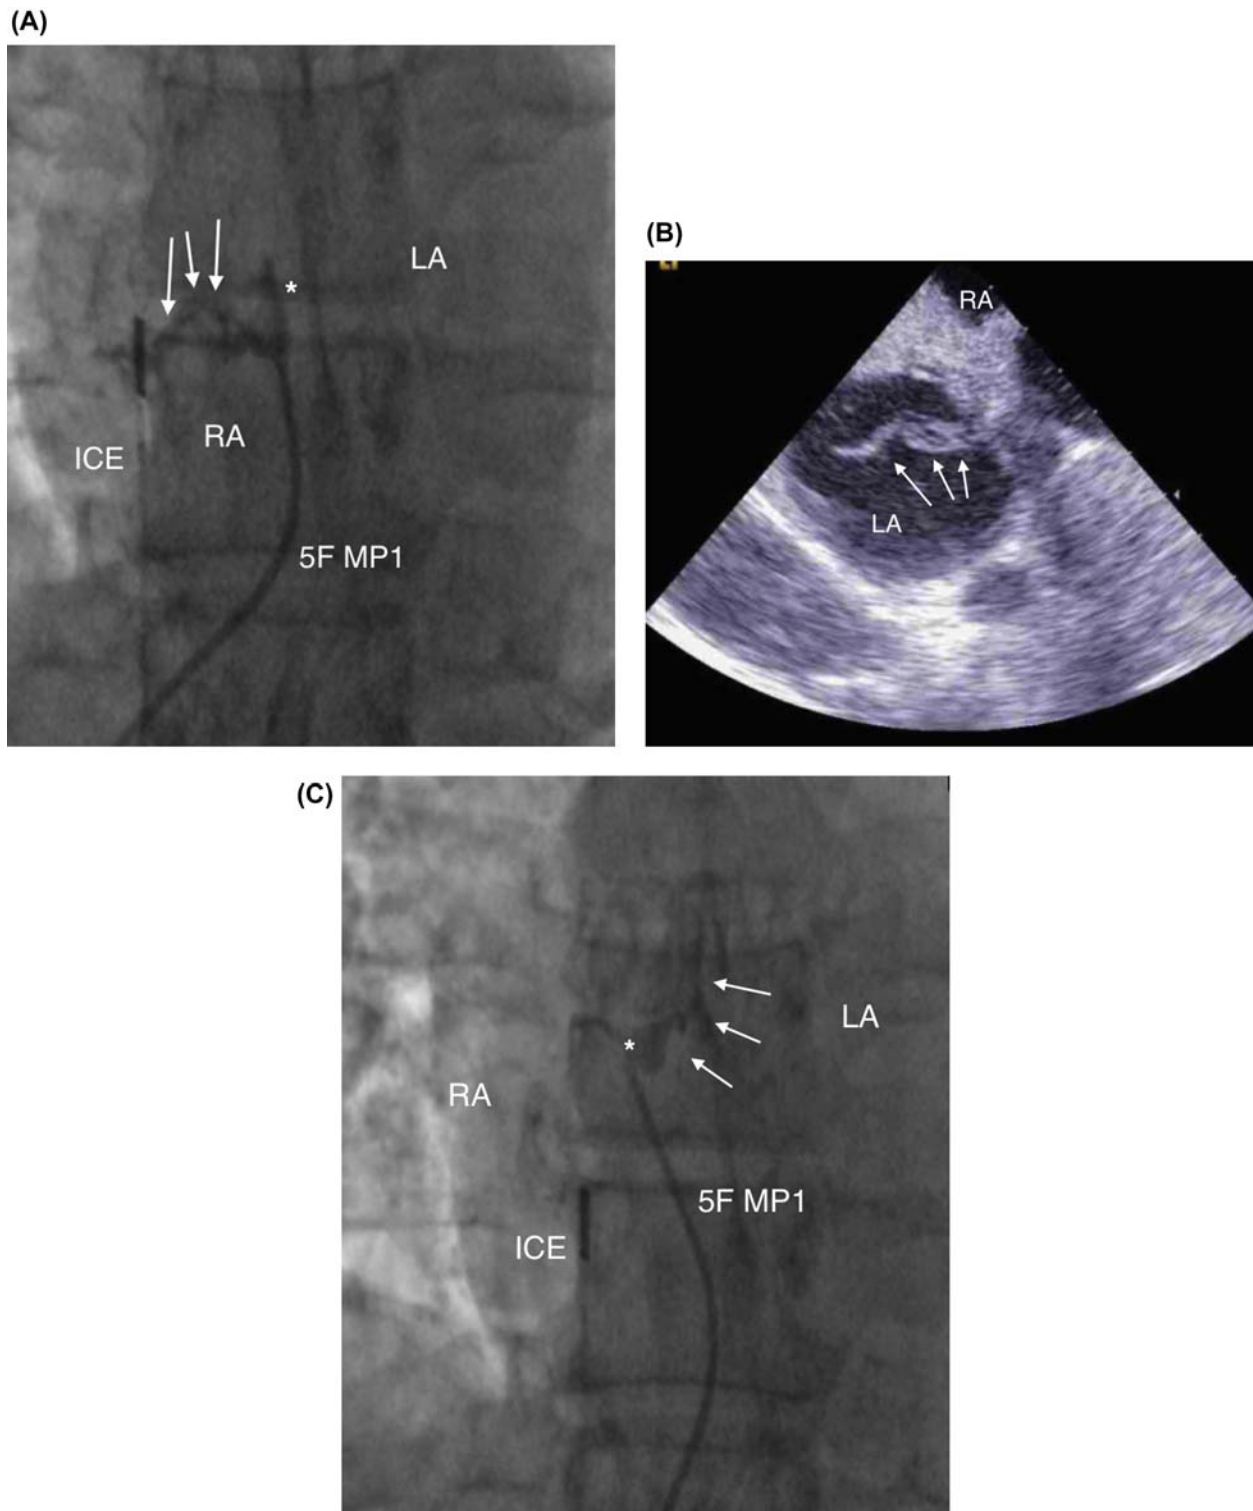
(A) Fluoroscopy of an intracardiac echocardiography (ICE) imaging catheter on the left side of the image with a 5F MP1 catheter engaged into the foramen ovale (asterisk), filling it with contrast medium and the contrast medium is seen spilling back (arrows) into the right atrium (RA) without any entering the left atrium (LA), suggesting a sealed foramen ovale pouch. (B) An intracardiac echocardiography image of the interatrial septum during agitated saline contrast medium injection under Valsalva release, showing a stream of bubbles (arrows) crossing from the right atrium (RA) to the left atrium (LA), confirming the presence of a PFO despite a negative radiographic contrast medium injection as seen in (A). (C) Once the 5F MP1 catheter was slightly withdrawn, rotated counterclockwise and readvanced into the PFO (asterisk), angiographic contrast medium flowed fully into the left atrium (LA) indicated by arrows. *ICE*, intracardiac echocardiography; *RA*, right atrium.
